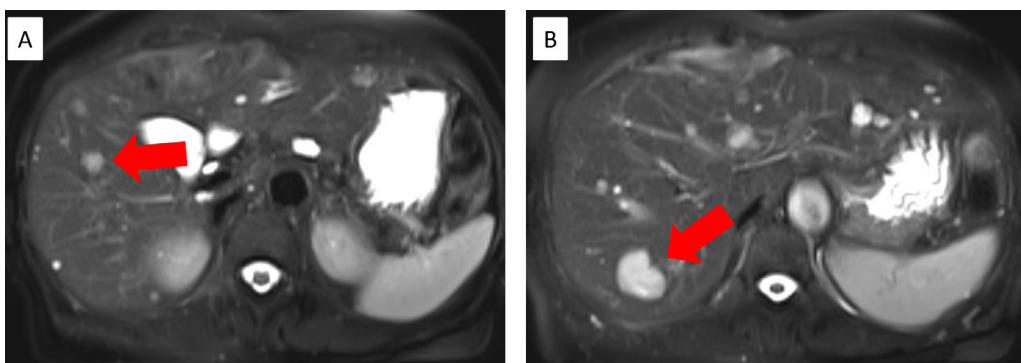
Magnetic resonance imaging of the liver reveals (A) a 10 mm mass in segment 5, and (B) a 26 mm mass in segment 7.
